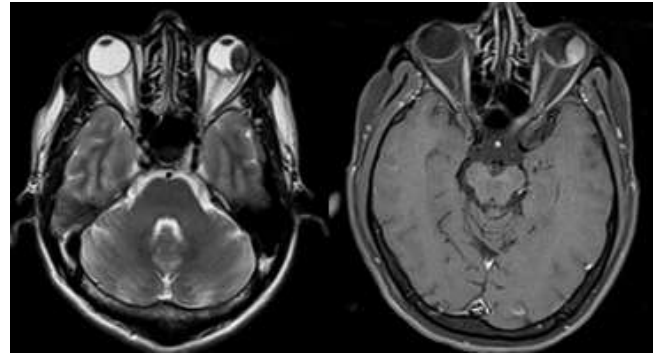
MRI orbit showing T1 hyperintense and T2 hypointense lesion with homogeneous enhancement noted in the left eye globe consistent with malignant melanoma
